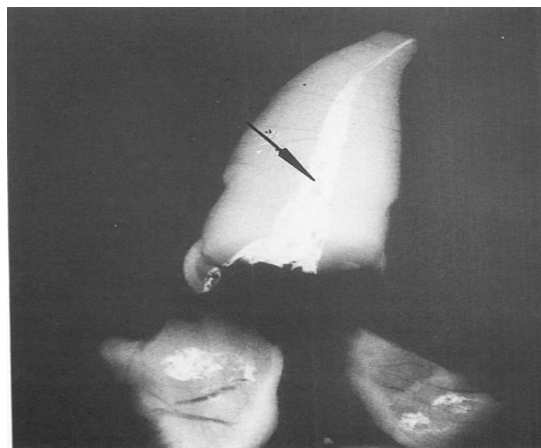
Radiograph of tooth heated to 538°C (1000°F). Note the radiopaque material in canal space which is almost identical to that in figure 15
